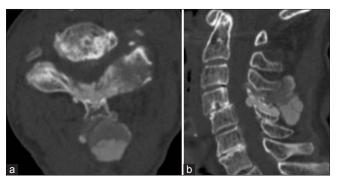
CT scans obtained 4 years prior to the current admission to evaluate neck pain (a and b). Subtle calcification of the yellow ligament was observed at the C3/4 and C4/5 levels
